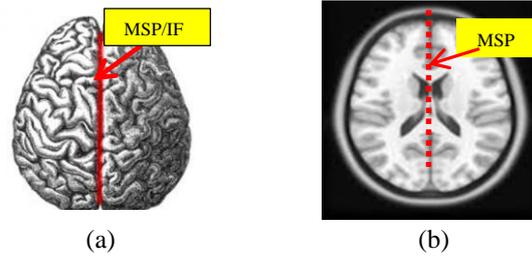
The human brain, (a) Medial inter-hemispheric fissure visible in red line, (b) T1-Weighted MRI brain axial slice with indicated the MSP by red dotted line.
